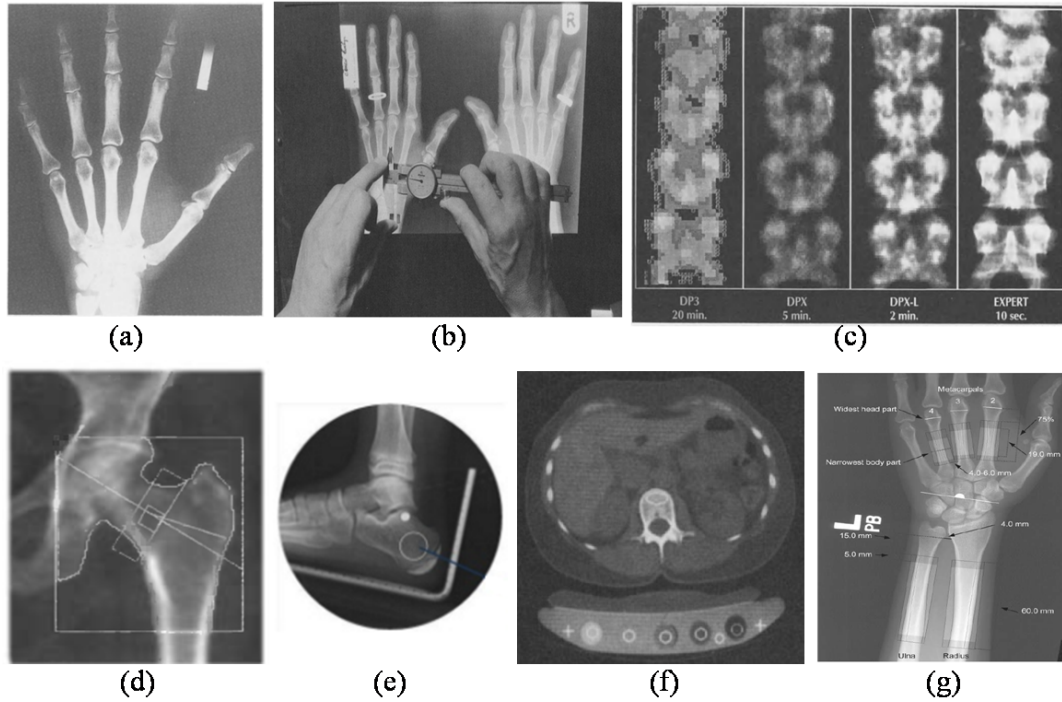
Quantitative imaging techniques used for diagnosis of osteoporosis: (a) Radiographic absorptiometry, (b) Manual radiogrammetry, (c) Photon and X-ray absorptiometry of lumbar spine, (d) DXA of proximal femur, (e) QUS of calcaneum, (f) QCT of spine and (g) DXR (Huddleston 1988; Bonnicksen 1998; Rosholm *et al.* 2001)
